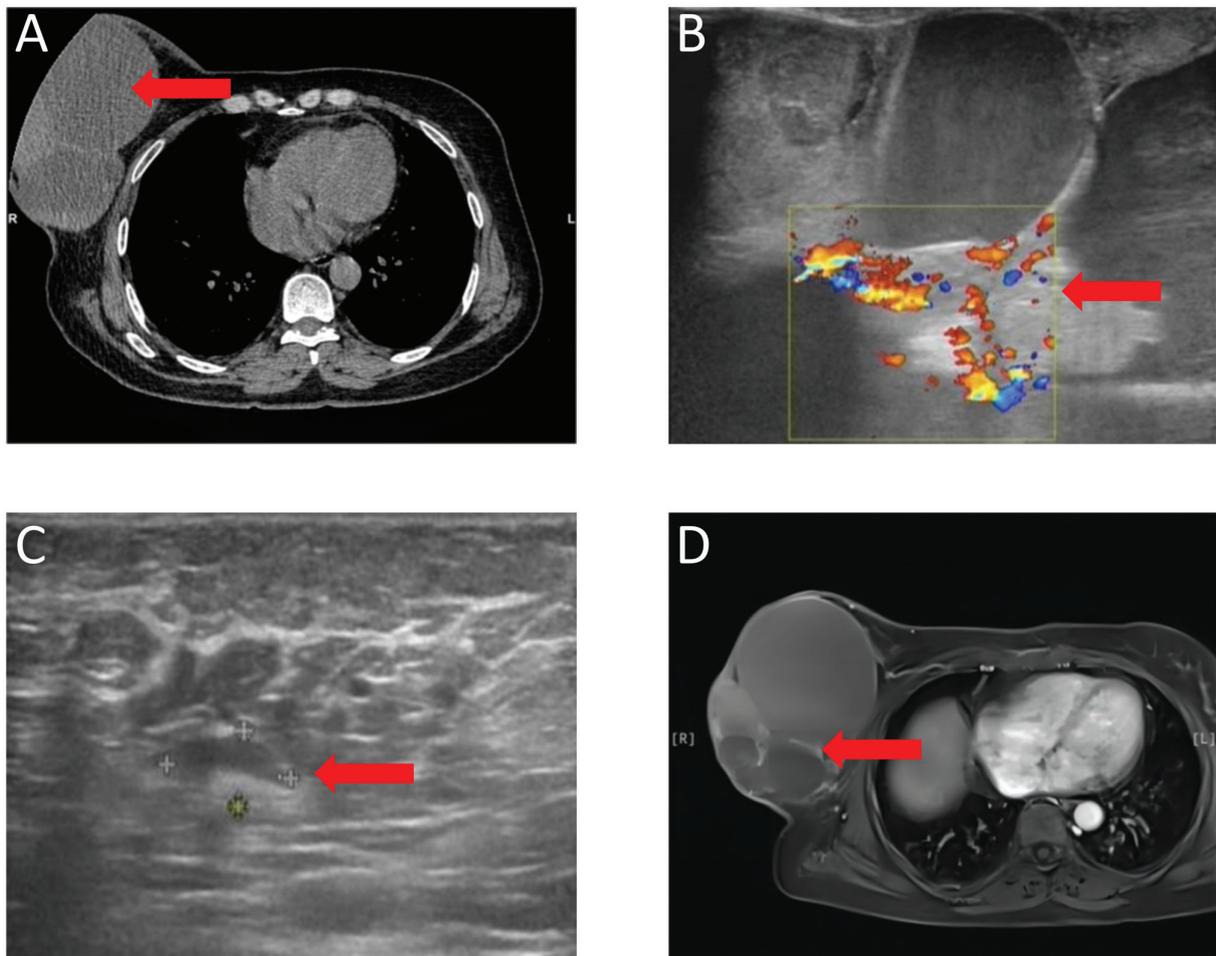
Results of the patient's preoperative imaging examination. (A) High resolution computed tomography of the thorax presented a large irregular low-density mass in the right breast (red arrow). Doppler ultrasound of the breast and axilla revealed (B) significant blood flow in the solid part of the lesion (red arrow) and (C) a lymph node measuring 1.09×0.61 cm (red arrow). (D) Magnetic resonance imaging indicated the presence of multiple cystic-solid lesions, some of which appeared to be fused (red arrow). The solid component showed inhomogeneous enhancement, and there was thickening of the skin.
